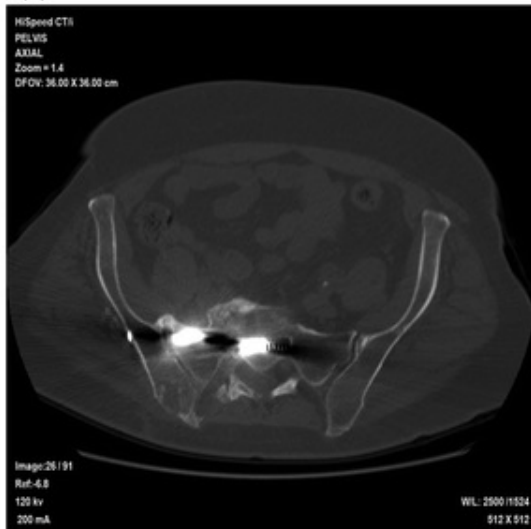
a Anteroposterior (AP) pelvis at presentation 2 years after the accident with pain in the sacrum treated previously with cannulated screws. b Axial CT scan showing nonunion of the sacrum. c Initial postoperative AP pelvis after open reduction internal fixation of the sacral nonunion with iliac crest bone graft and burring sacrum for bleeding bone through a posterior approach. d AP pelvis 1 year postoperative showing no lucency around the screws and solid fixation. Patient ambulating with foot pain with minimal pelvic pain. e Axial CT 6 months postop showing bridging bone
